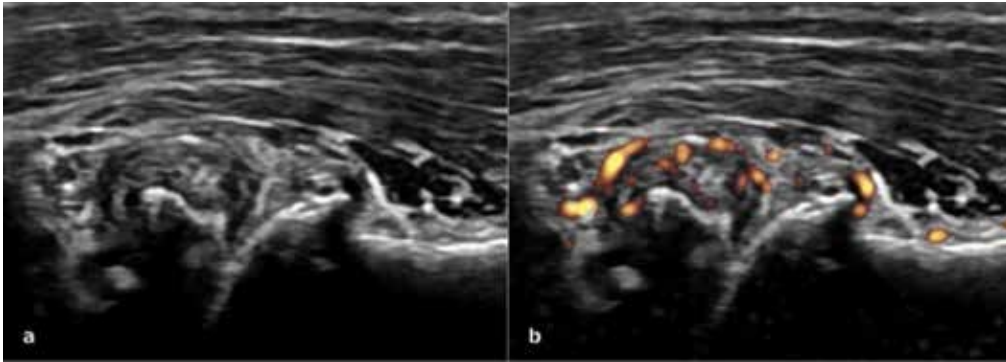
a Osteophyte and synovial proliferation in the first carpometacarpal joint. b Power Doppler signal was found in the proliferative synovial tissue. a, b Longitudinal scans.
